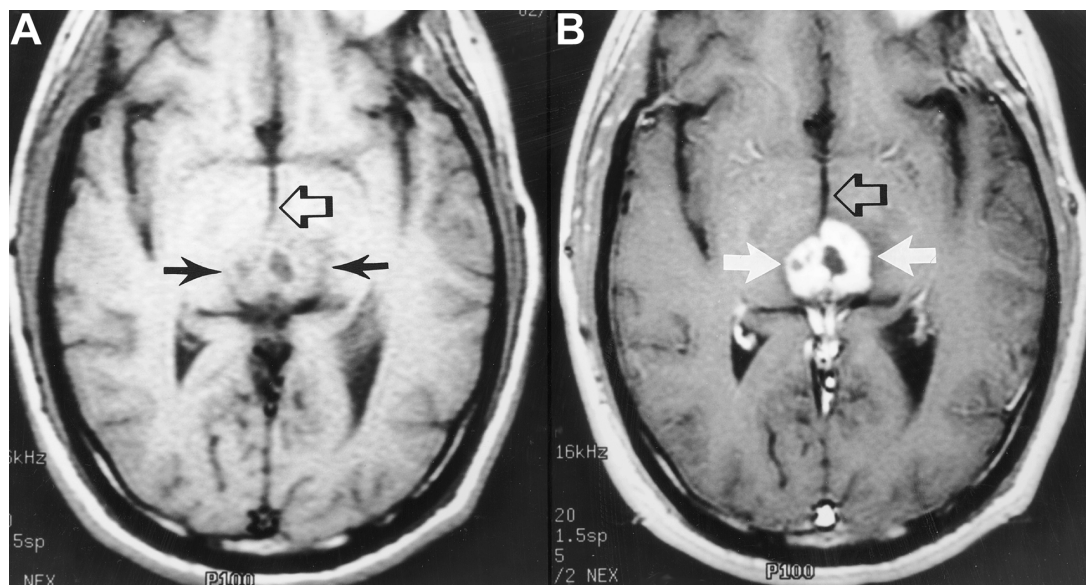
Pineal mass (germinoma). Pre-contrast (A) and post-contrast (B) MRI scans reveal enhancing posterior third ventricular and pineal region mass (arrows) produced by pathologically proven germinoma. Open arrows in A and B point to the anterior portion of the third ventricle.
